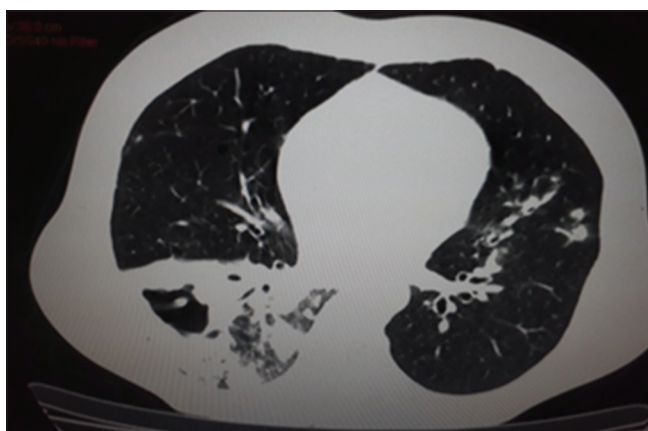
Computed tomography thorax lung window image showing cavitary lesion in right lung with surrounding confluent nodules
